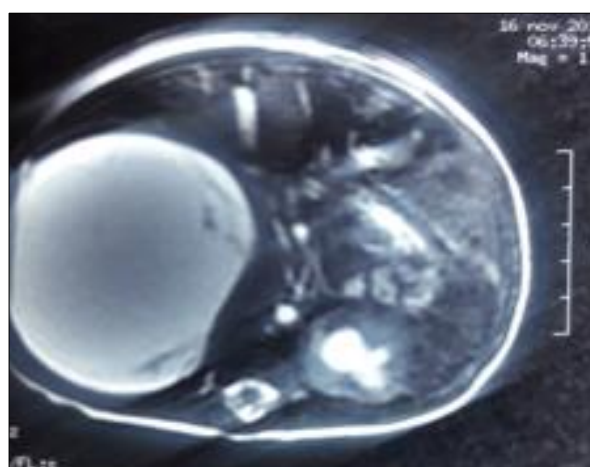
MRI showing a huge cystic lesion with internal septa located in the perirenal space with compressed renal parenchyma in front of the mass.
